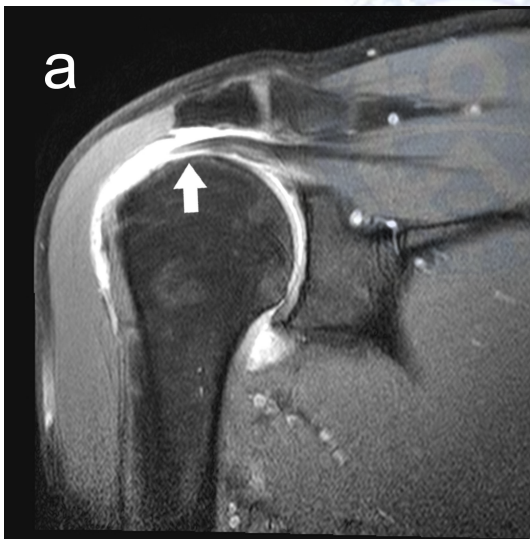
56-year-old woman with non-traumatic rotator cuff tear. Torn tendon with tapering edge (white arrow) on the fat-saturated T1-weighted oblique coronal image.
